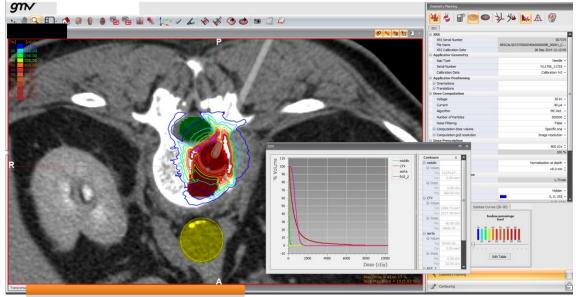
Isodose distribution on CT images acquired in prone position in previsional calculation related to the hypothetical irradiation source position, by using a dedicated software, in the pre-operative study relative to vertebral tumor treatment with Kv-IORT (photo by R.Lazzari)
